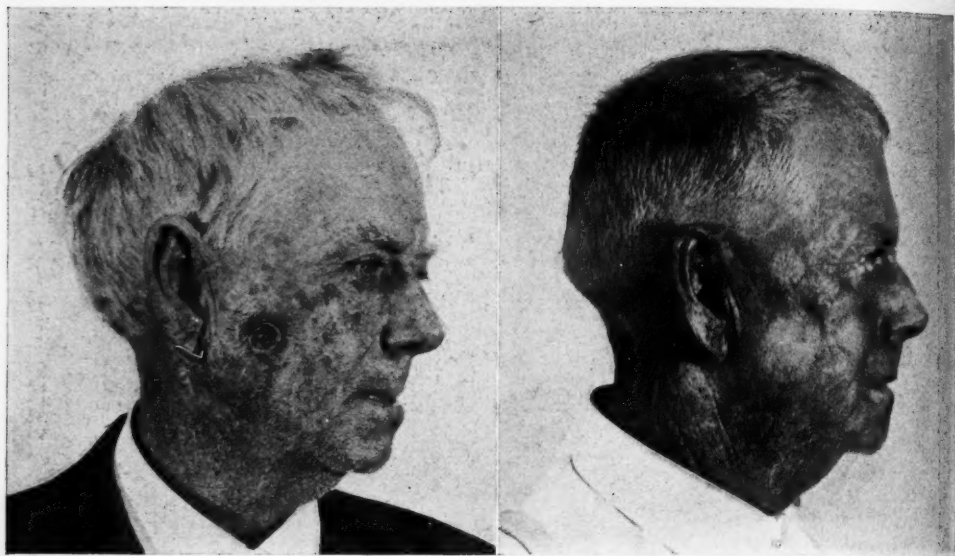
Farmer, age 64. Was first seen January 6, 1925. Family history: Grandmother died from cancer of nose. Personal history: Seven years before he was first seen a scaly patch appeared on right side of face. Was treated with some sort of plaster. Two years before examination a papular growth appeared on site of former lesion. At time of his first visit there was an ulcerated lesion on side of face about the size of a twenty-five cent piece (Fig. 3A, left). Edges were elevated, indurated and rolled outward. Clinical diagnosis was basal cell carcinoma. Six double erythema doses of X-rays, through a cone three-quarters inch in diameter, caused ulcer to heal. The second photograph (Fig. 3B, right) was made December 27, 1925. At this time skin was soft and smooth over site of former growth.
